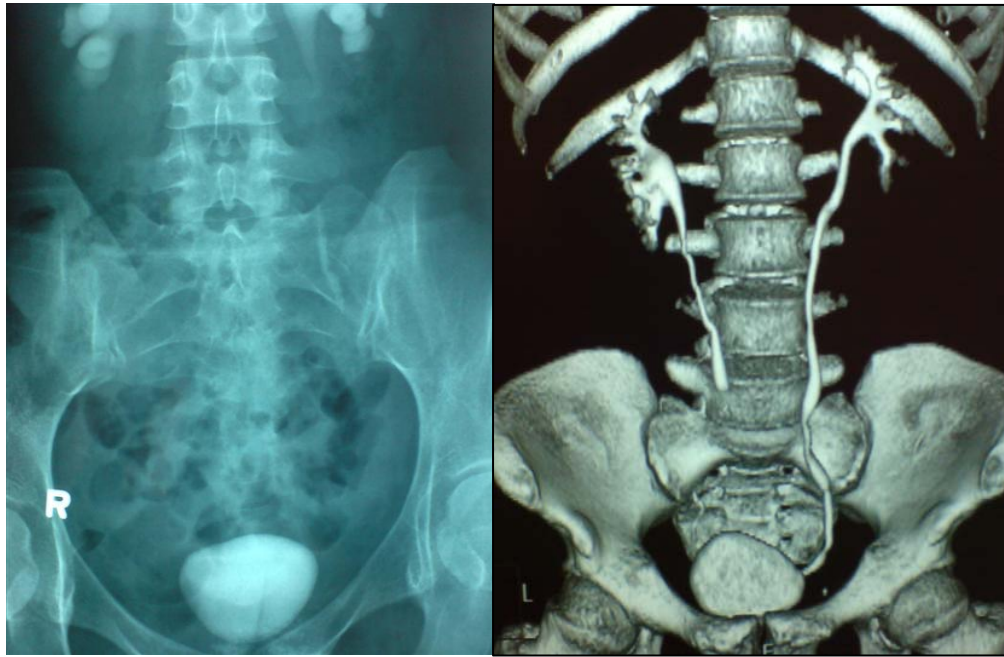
Intravenous urogram (left) and computed tomography (right) of a two ketamine abusers showing small bladder and prominent bilateral upper tracts.
